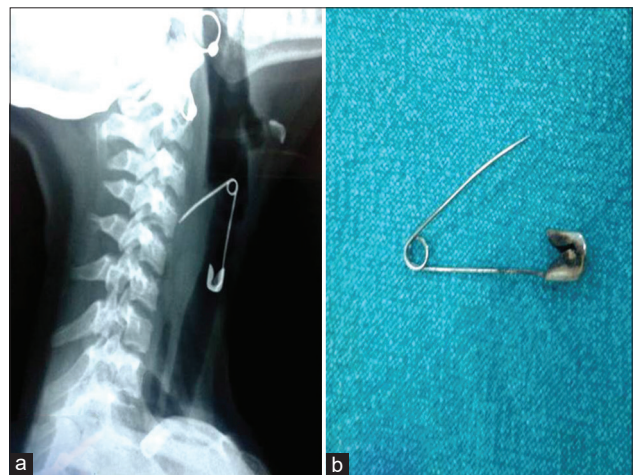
(a) X-ray of the soft tissue of neck (lateral view) showing an open safety pin; (b) an open safety pin removed from the larynx
